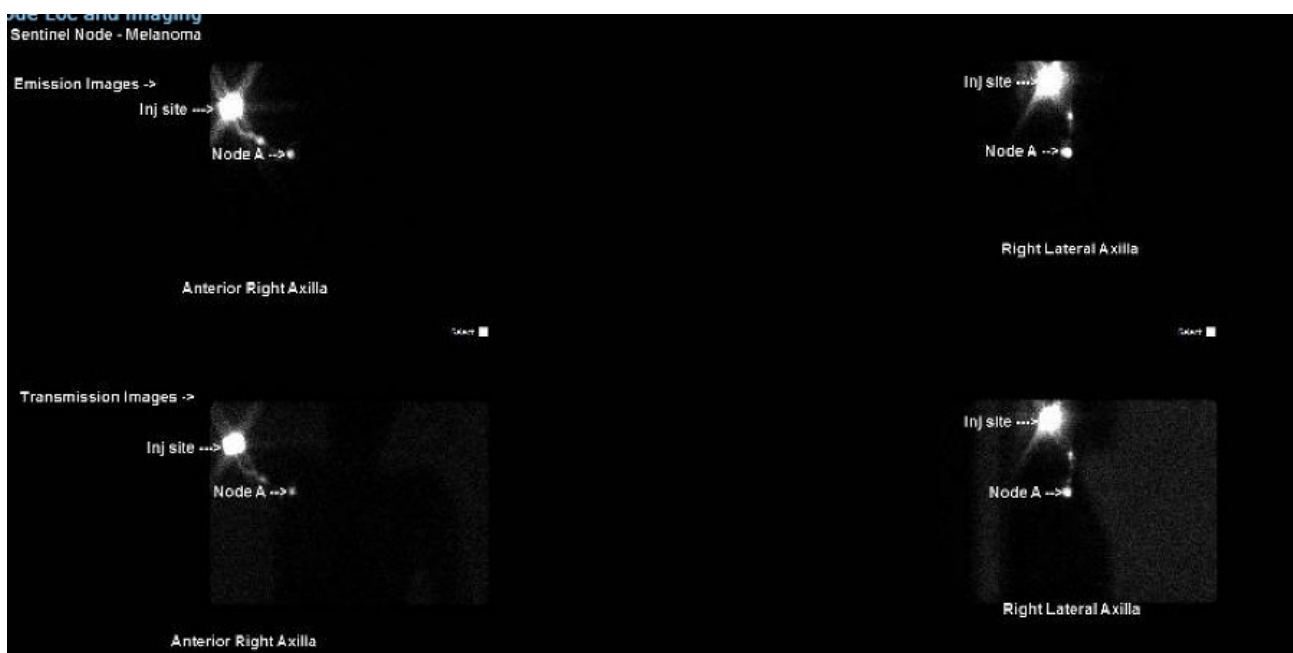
Pre-wide local excision lymphoscintigram demonstrating a single axillary sentinel lymph node.
